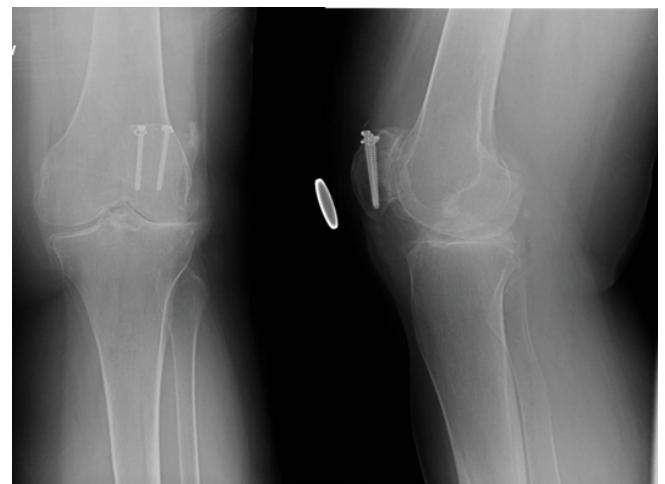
Anteroposterior and lateral plain film radiographs of a hybrid fixation using cannulated screws.
